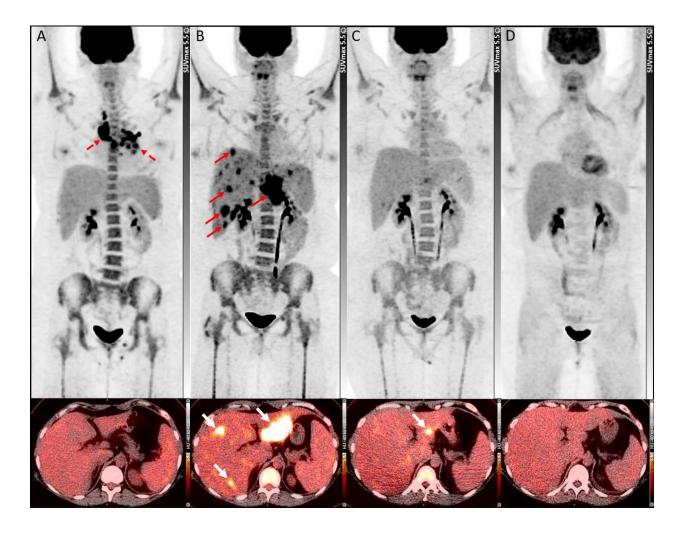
¹⁸F-FDG PET/CT maximum intensity projection (top) and fused PET/CT transaxial images (bottom) at baseline (A) show hypermetabolic mediastinal lymphadenopathy (dashed-arrow). ¹⁸F-FDG PET/CT performed at six weeks after treatment with Pembrolizumab (B) shows metabolic resolution of the mediastinal lymphadenopathy and interval development of multiple discrete hypermetabolic lesions in the liver (solid-arrows). ¹⁸F-FDG PET/CT performed five weeks after discontinuation of Pembrolizumab and treatment with Prednisone shows significant improvement in the liver lesions (C) which resolved completely at eight weeks (D).
